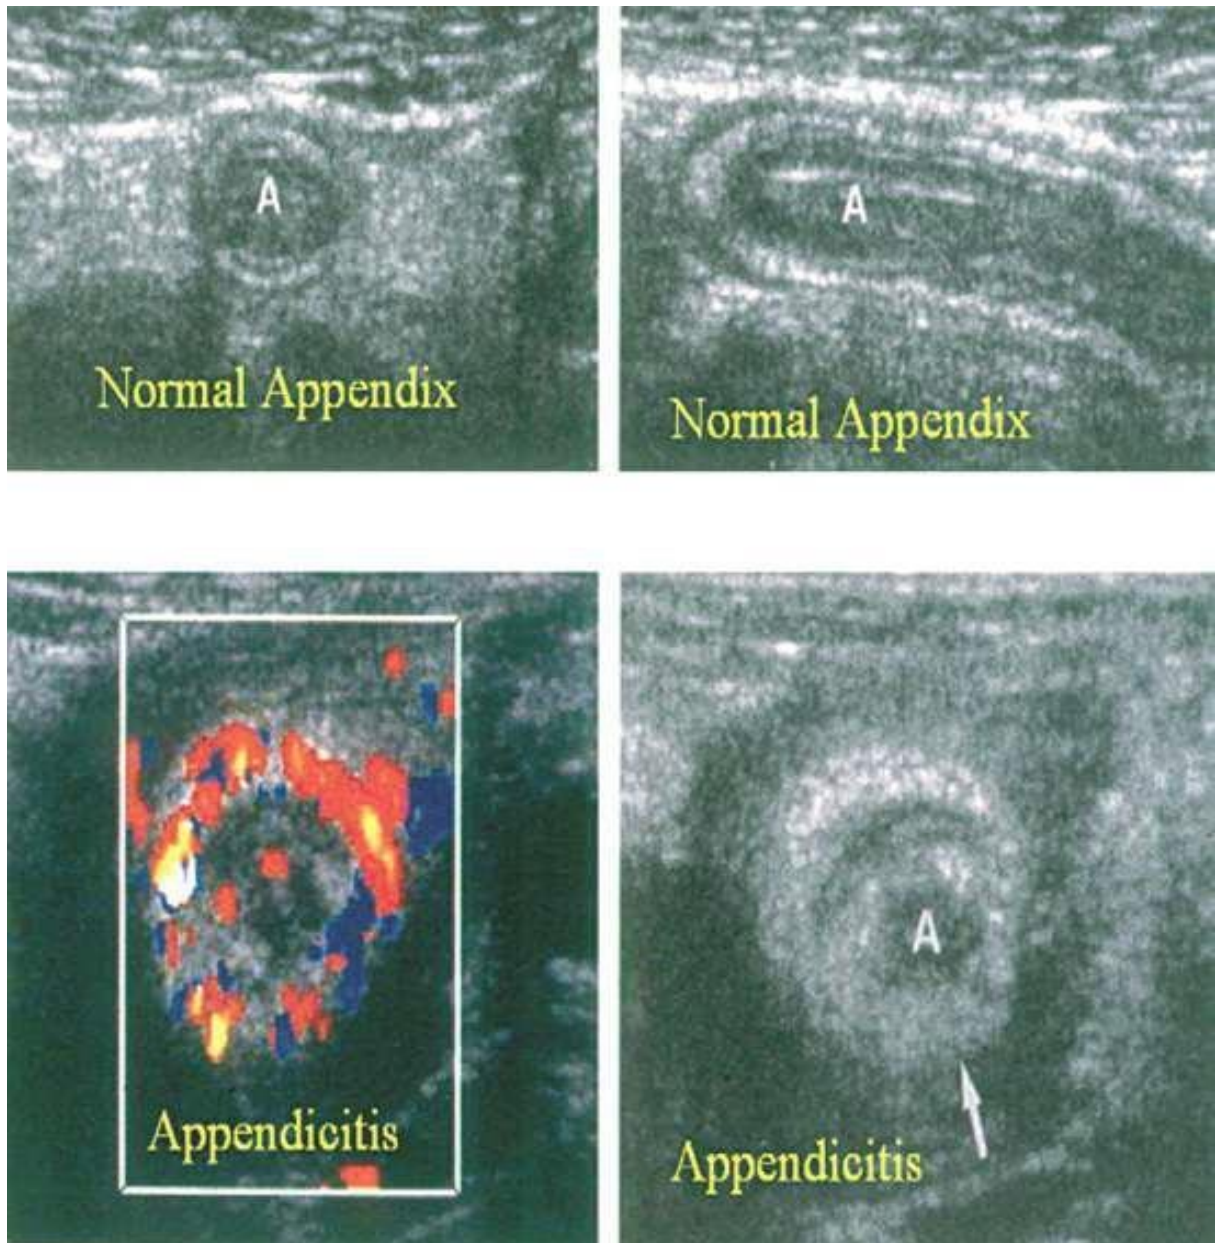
Ultrasonography images of appendix
